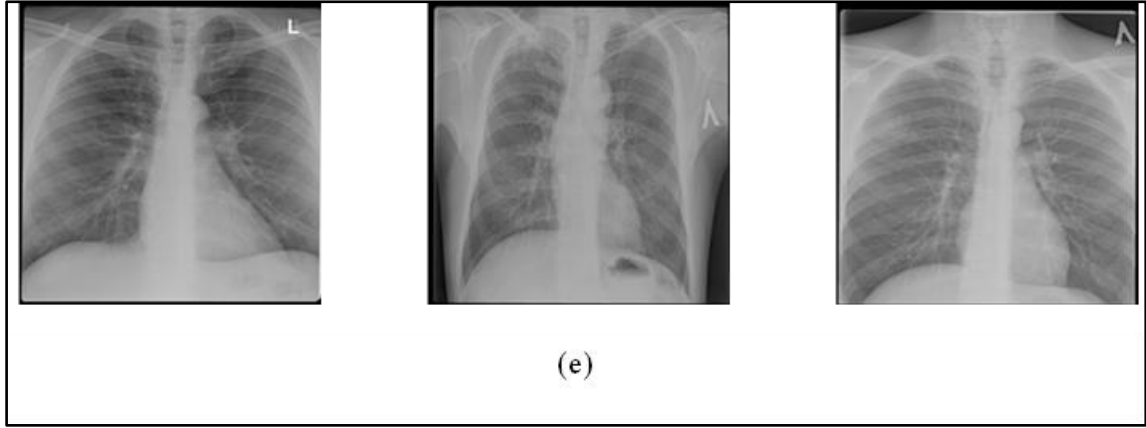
Chest Radiographs samples; (a) Cardiomegaly, (b) COVID, (c) Normal, (d) Pneumonia, and (e) Tuberculosis.
